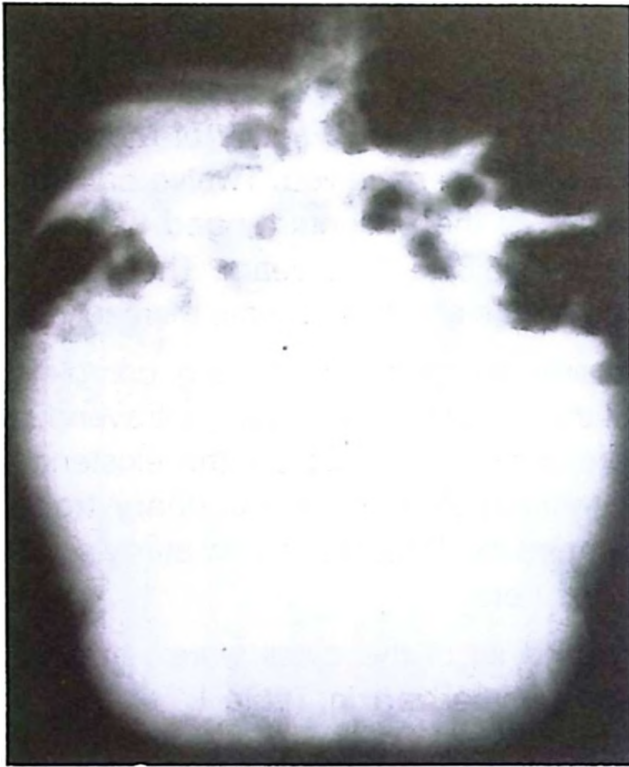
Plain abdominal radiograph showing space-occupying mass effect displacing the bowel gases.
